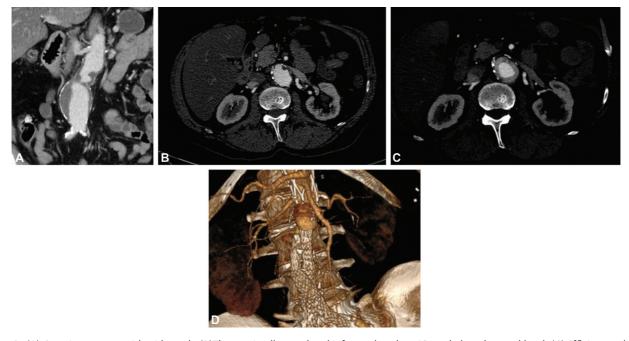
(A) Case 1 aneurysm with wide neck. (B)The proximally angulated infrarenal neck at 10mm below the renal level. (C) Efficient sealing relies on the adjusted apposition on the conical neck irregularities. (D)The postoperative computed tomography angiography at one month shows efficient apposition of the inflatable rings at the sealing level, with no endoleaks.
